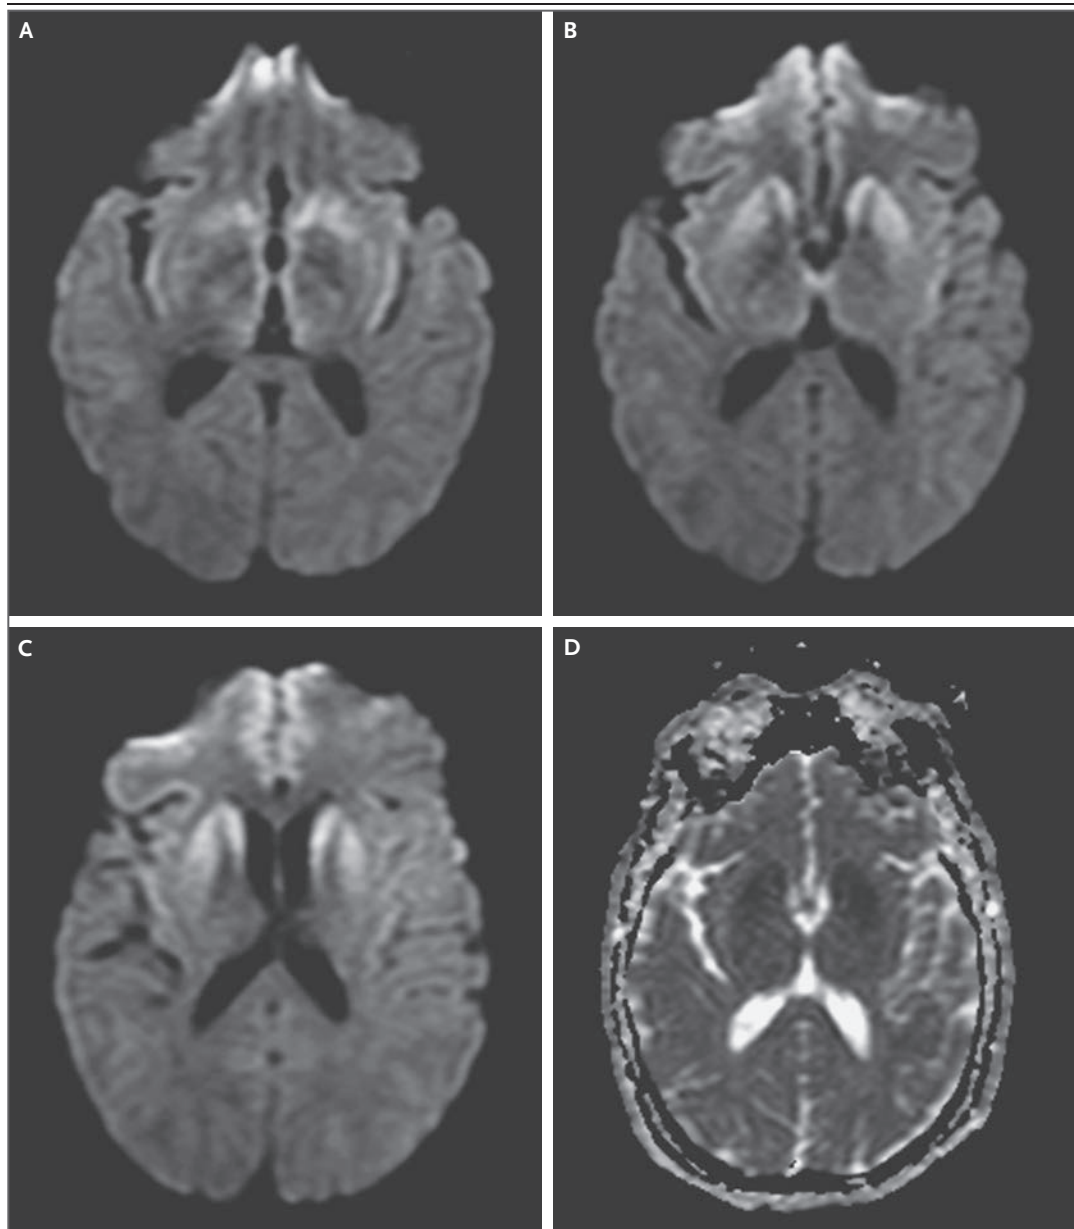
MRI of the Brain.
